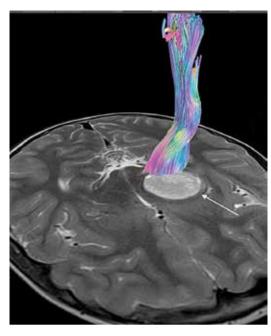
Preoperative magnetic resonance imaging in T2 mode (axial section): tumor of the basal ganglia (posterior leg of the internal capsule, globus pallidus), thalamus of the left hemisphere and lateral parts of the left brain stem (indicated by an arrow) is adjacent to the left corticospinal tract
